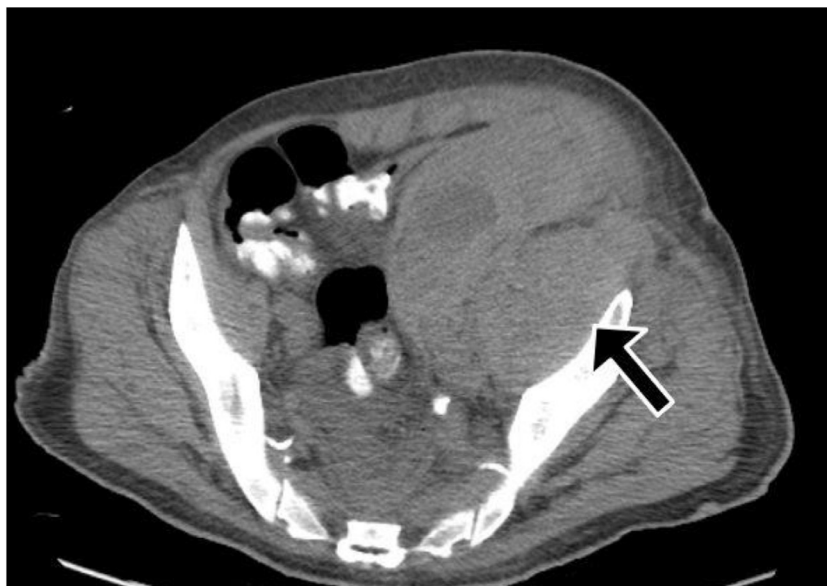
CT scan of abdomen and pelvis showing marked swelling of the left psoas and left iliacus with mass-effect on the adjacent bowel with heterogeneous density indicative of hemorrhage.
